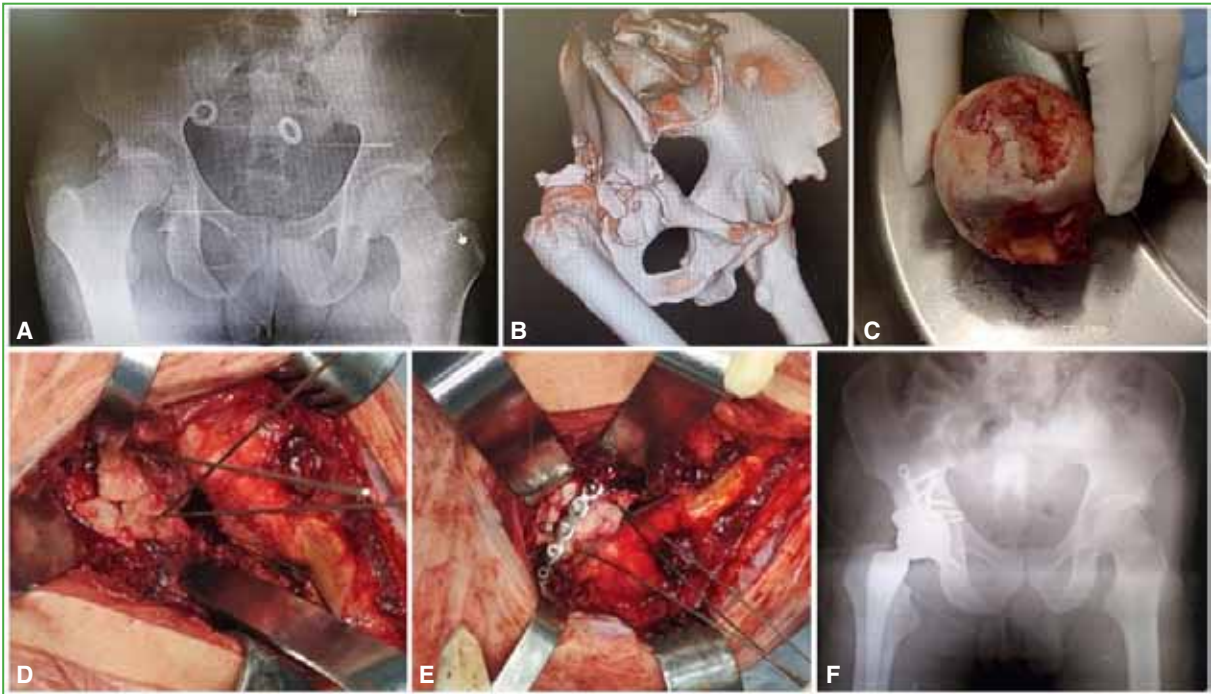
59-year-old man with acetabular fracture-dislocation due to a traffic accident, with more than 30 days of evolution. A. Anteroposterior radiograph of the pelvis. B. Tomography with 3D reconstruction showing a fracture-dislocation of the posterior wall and column. C. Image showing a severe osteochondral lesion of the femoral head. Osteosynthesis plus total hip arthroplasty is indicated in one stage. D and E. Intraoperative images: wall reduction and provisional posterior column fixation with a 3.5 mm reconstruction plate. F. Postoperative anteroposterior pelvis radiograph showing cementless total hip arthroplasty. Excellent outcomes were achieved by the end of the study.
